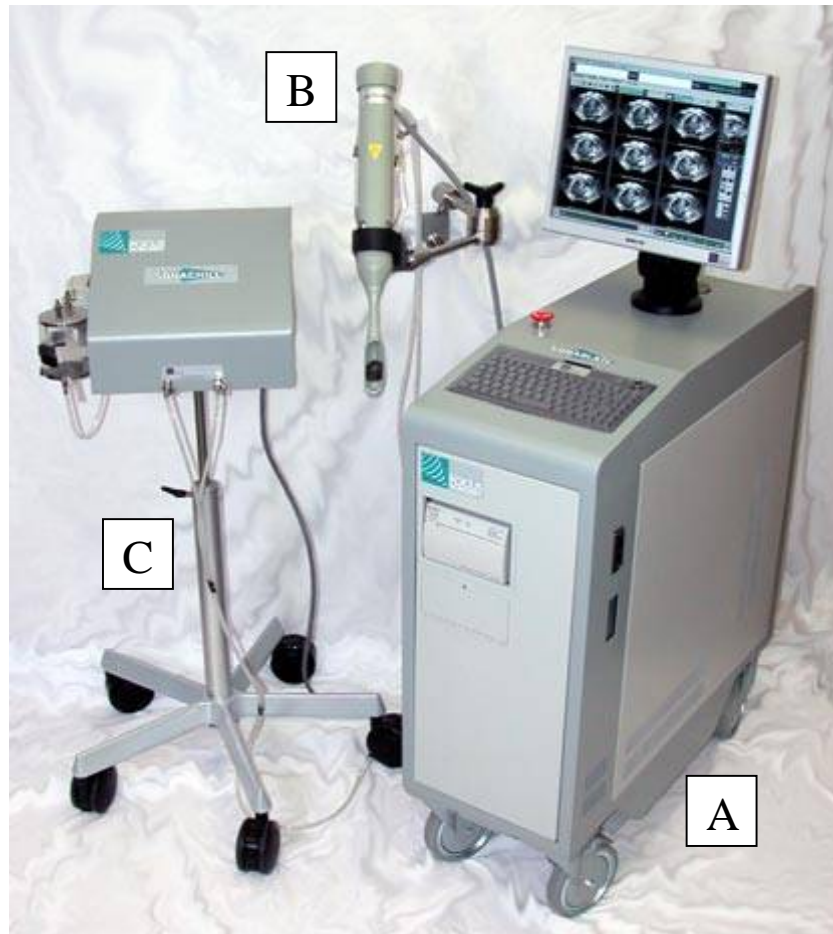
The Sonablate-500 (Focus Surgery, IN, USA) with (a) treatment console and ultrasound generator, (b) diagnostic/therapeutic probe and (c) water cooling unit (the 'Sonachill').
